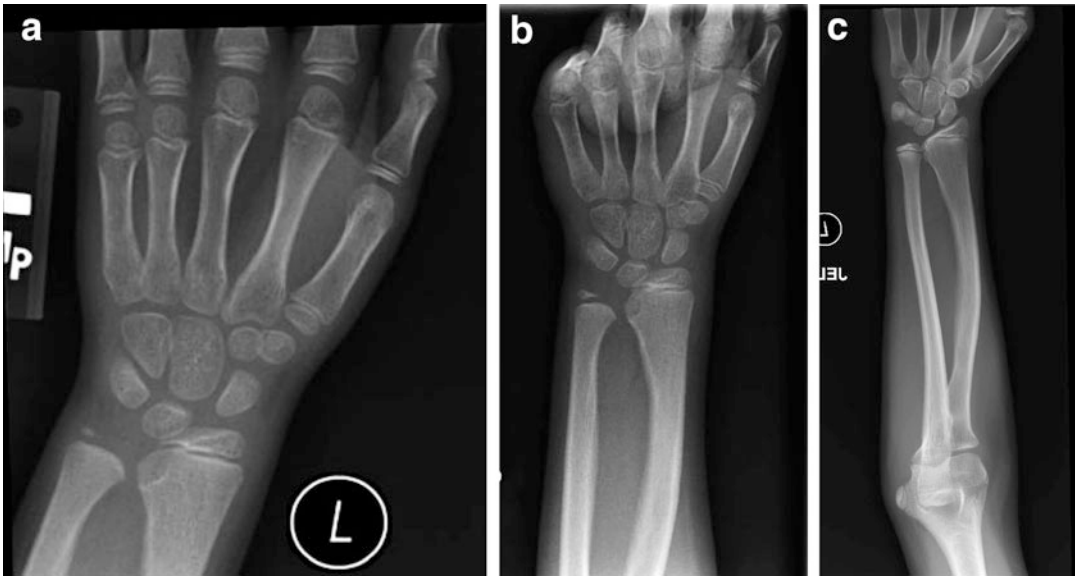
Serial radiographs of a patient showing no progression of deformity over time
